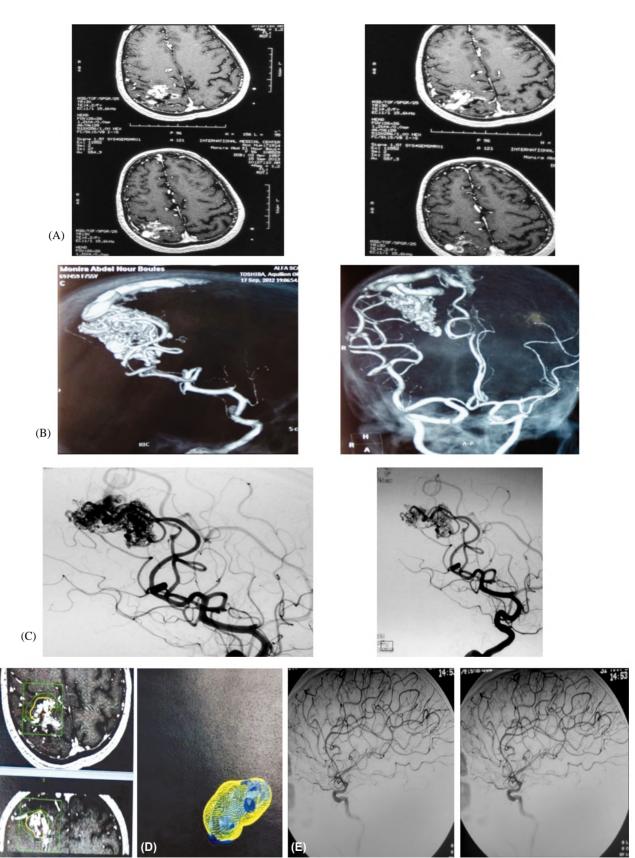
(A) Non contrasted C.T brain: Showing Rt occipital ICH with intraventricular extension, (B) T2WI axial MRI cuts: Showing the AVM diffuse nidus. (C) 3D MR angiogram anteroposterior and lateral views showing the nidus (D) Anteroposterior and lateral carotid angiograms; showing sizable residual of the AVM nidus suitable for SRS. (E) Follow-up carotid angiogram (A-P & Lateral) views 36 months after stereotactic Gamma Knife; showing AVM nidal residual (arrow) for further management by another session of Gamma Knife.
